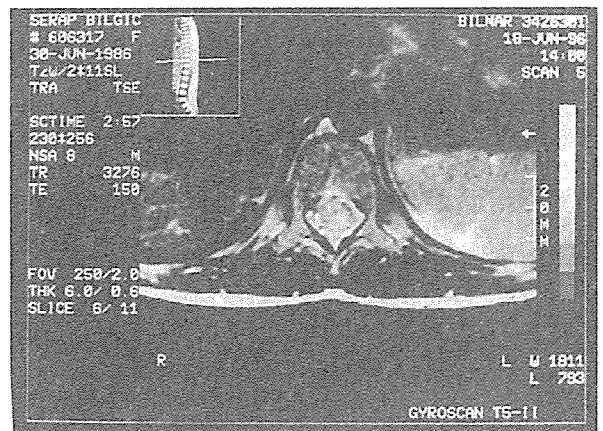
B. Same lesion appears hyperintense on T2-weighted axial cut.
